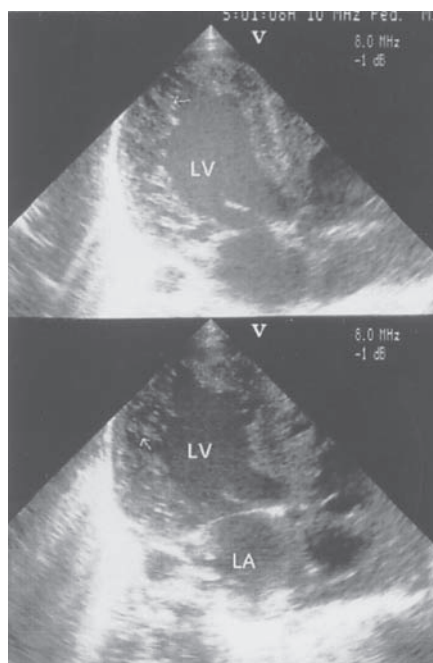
Postnatal echocardiographic examination showing prominent deep recesses communicating with the ventricular cavity at left ventricular apex and lateral wall. LV: Left ventricle. LA: Left atrium.
